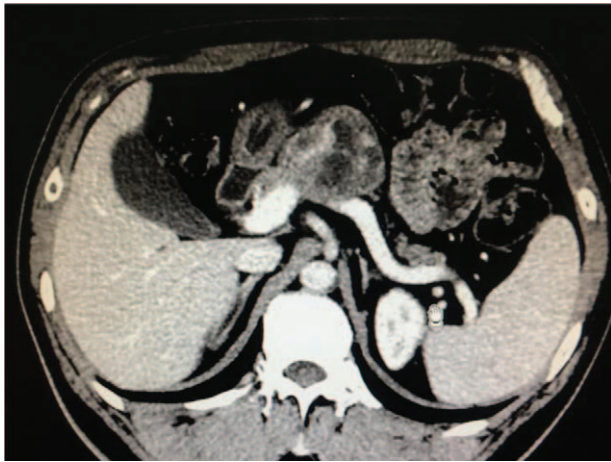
Enhanced CT scan of the MCN (delayed phase). CT=computed tomography, MCN=mucinous cystic neoplasm.
